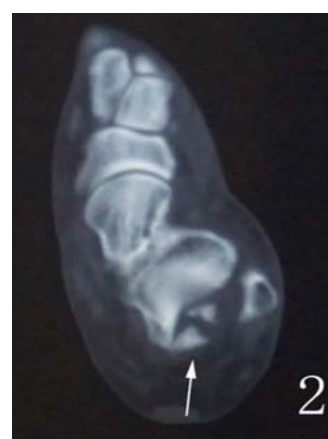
CT axial scans showing the neat and sharp fracture surface.
